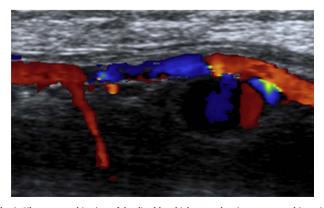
Ultrasonographic view of the distal brachial artery showing an outpouching with classical "ying-yang" pseudoaneurysm appearance on Doppler view due to turbulent blood flow.
